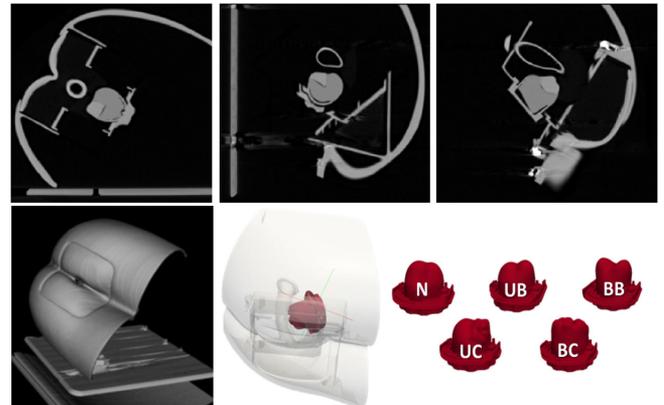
Sample scan planes of the DRE benchtop model CT (above) and segmented 3D models of skin and prostate (below): Normal (N), Unilateral Benign (UB), Bilateral Benign (BB), Unilateral Carcinoma (UC) and Bilateral Carcinoma (BC).
